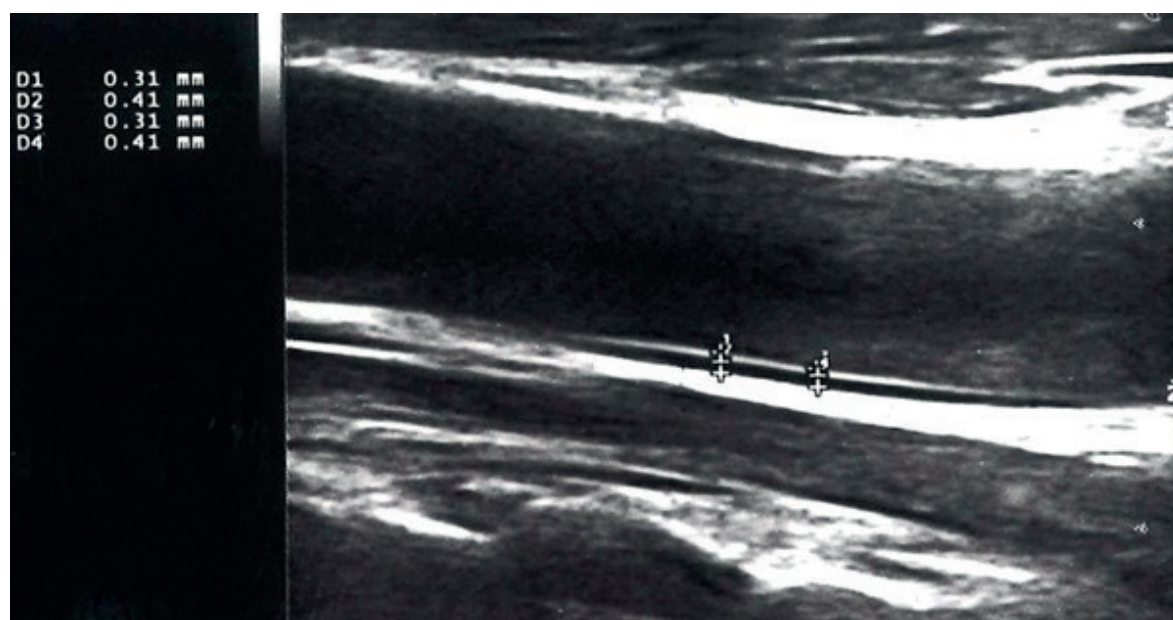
Doppler Ultrasonography image of the thickness of carotid intima media
